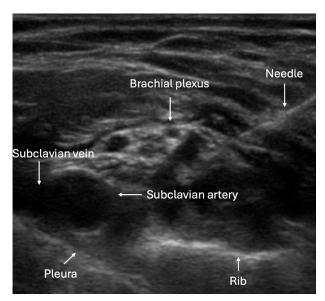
Ultrasound-guided peripheral nerve block. Left-sided brachial plexus trunks are visualized.
